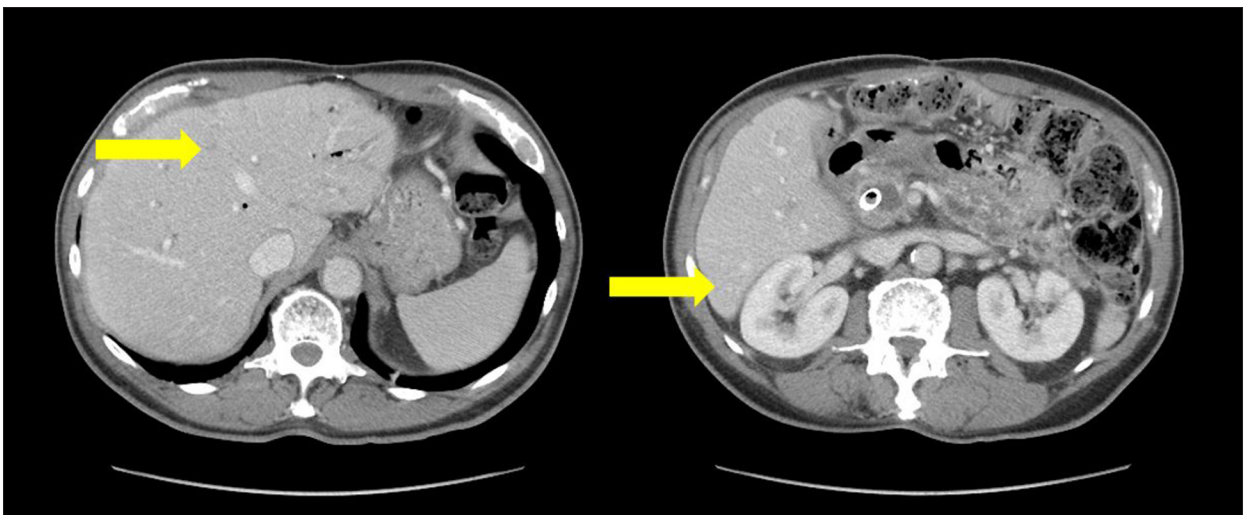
Computed tomography scan of the abdomen performed 11 months after 1 cycle of immunotherapy showing continued decrease and resolution of multiple hepatic lesions consistent with persistent treatment response as shown using arrows.
